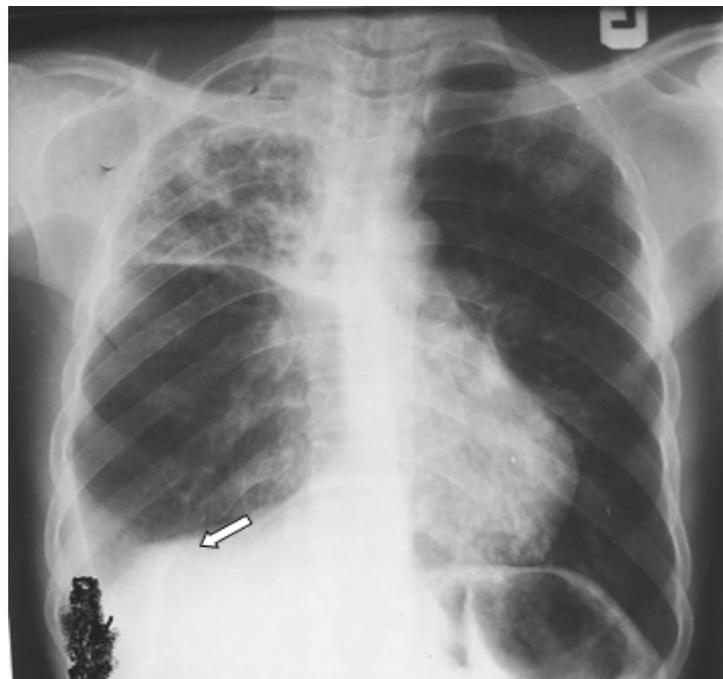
A posteroanterior chest radiograph taken three years prior to presentation showing fibrocavitary lesions involving the right upper lobe bounded inferiorly by the transverse fissure. A homogenous opacity blunting the right costophrenic sulcus and tracking along the right lateral chest wall indicating pleural fluid was noted (white arrow).
